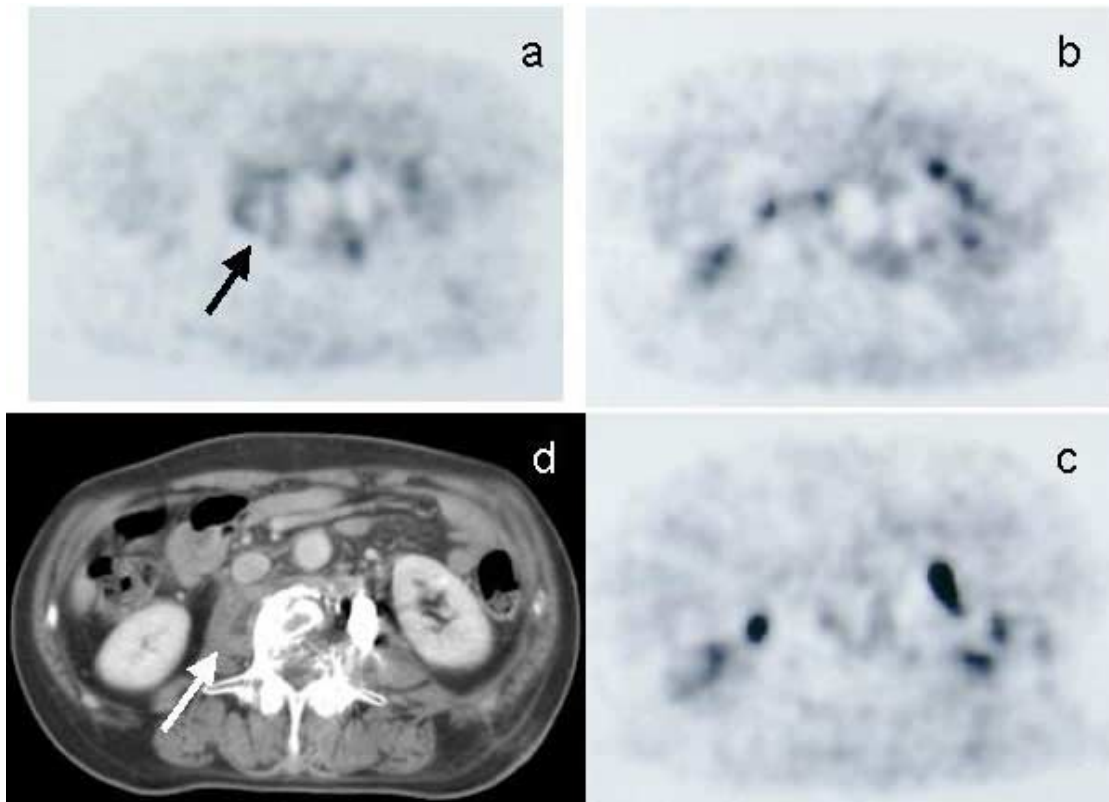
Case 2, FDG PET showed moderate accumulation corresponding to the capsule of the abscess (*arrow*), low uptake in the abscess center, and moderate uptake lesions in the left vertebrae, consistent with tuberculosis lesion of the vertebrae (a–c). Contrast enhanced CT showed abscess formation in the right iliopsoas muscle (*arrow*), and destruction of the vertebral bone (d).
